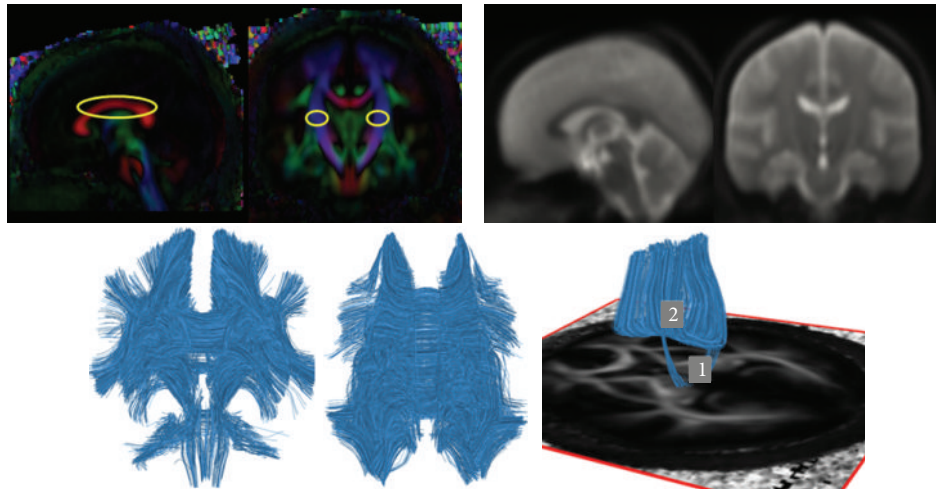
Upper row: color-coded FA map calculated from the ICBM DTI-81 atlas (left). Sagittal and coronal sections of T2-weighted images of the atlas (right). Lower row: extracted fiber tracts from the ICBM DTI-81 atlas in the whole brain. Rear view (left) and top view of the extracted fiber tracts in the whole brain (middle). Note the isolated CC and CS tracts (right).
